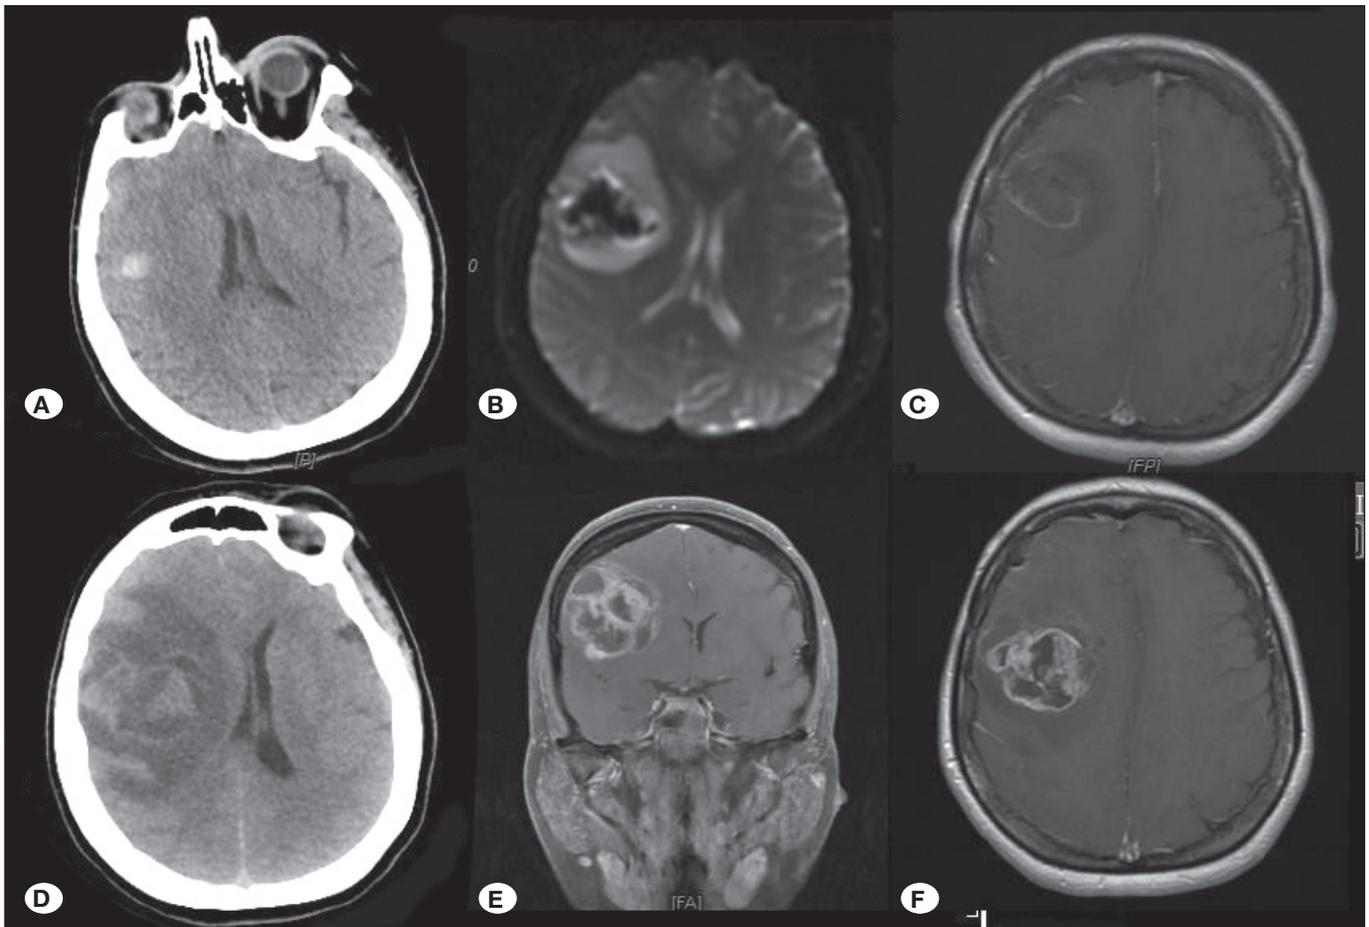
A) Axial section CCT, B) axial section diffusion MRI, C) axial section contrast enhanced T1W brain MRI D) 1st month axial section BBT, E) 1st month coronal section contrast enhanced T1W brain MRI, F) 1st month axial T1W contrast enhanced brain MRI section.
